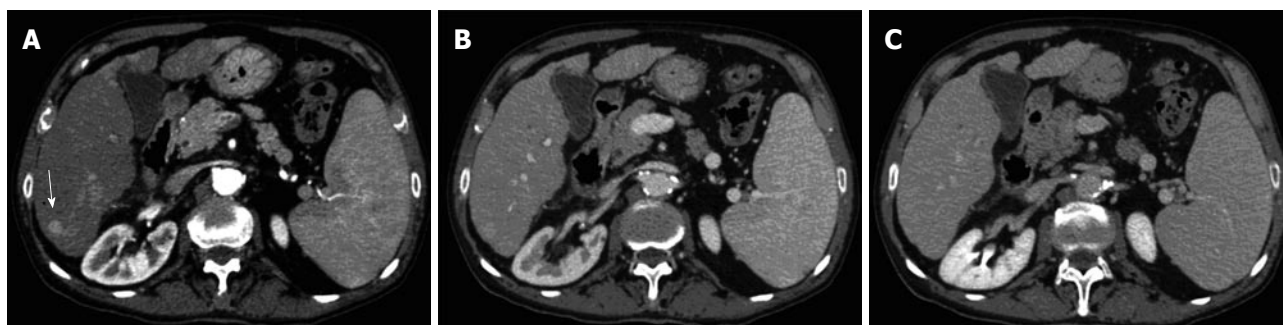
Computer tomography scans of the abdomen performed on admission. A: Arterial phase computer tomography (CT) scan shows small hepatocellular carcinoma nodule with mild enhancement (arrow) in right liver lobe; B: Hepatic venous phase; and C: Delayed phase CT scan at same level shows isoattenuation of lesion to liver parenchyma.
